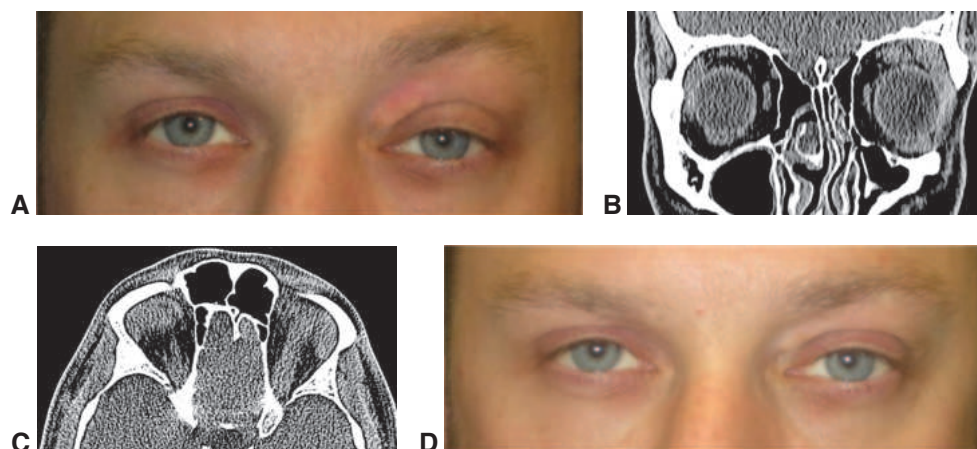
Immunoglobulin G4–related disease (IgG4-RD) of the lacrimal gland. A, Photograph of a patient with left-side proptosis. B and C, Axial and coronal CT imaging studies, respectively, show enlargement of the left lacrimal gland region. D, Patient improvement after immunosuppressive treatment. (Courtesy of Julian D. Perry, MD, and Alexander D. Blandford, MD.)
